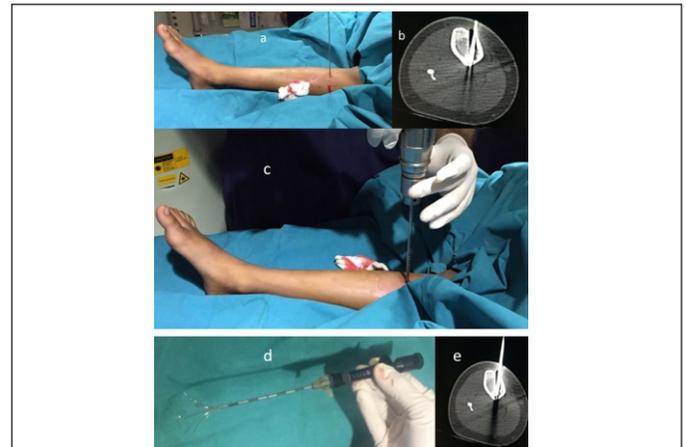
Computerized tomography (CT)-guided introduction of guide wire for osteoid osteoma lesion in tibia (a and b), drilling over guidewire (c), radio frequency probe (d) and confirmation of probe tip under CT guidance (e).
